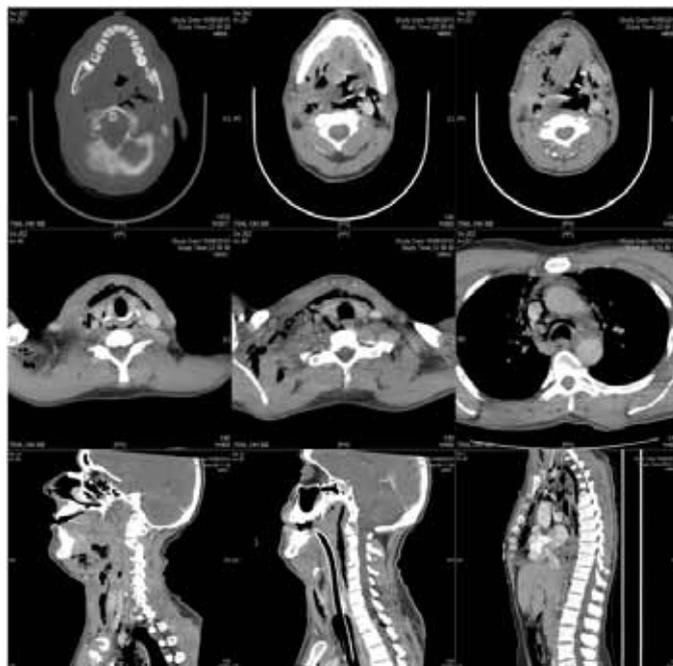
Contrast computed tomography scan. Coronal and sagittal cuts displaying a preoperative carious right mandibular second molar, extensive gas locules demonstrated within the parapharyngeal, pre-vertebral, submandibular and submental regions, the subcutaneous fat of the neck and carotid spaces. This extends into both the anterior and posterior mediastinum as well as the right axilla.
